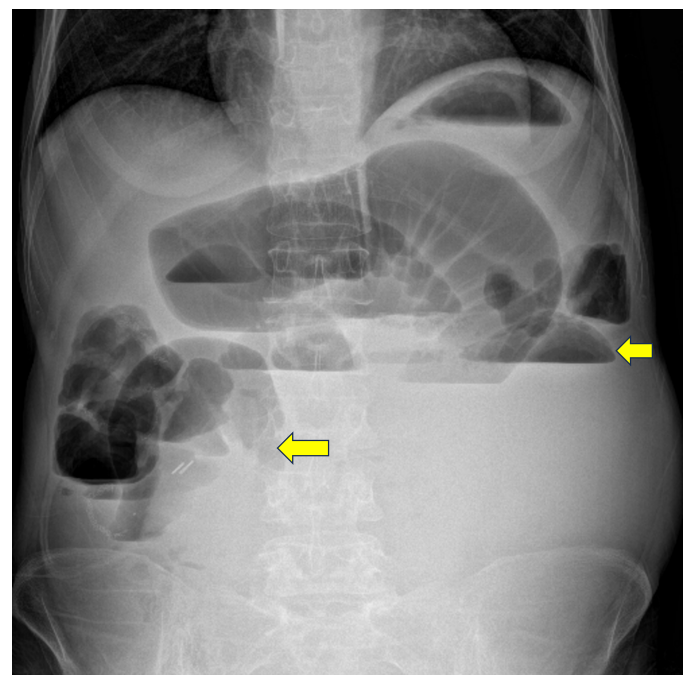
Abdominal X-ray image of patient 2. Diffuse air-fluid levels (arrows) are observed.
